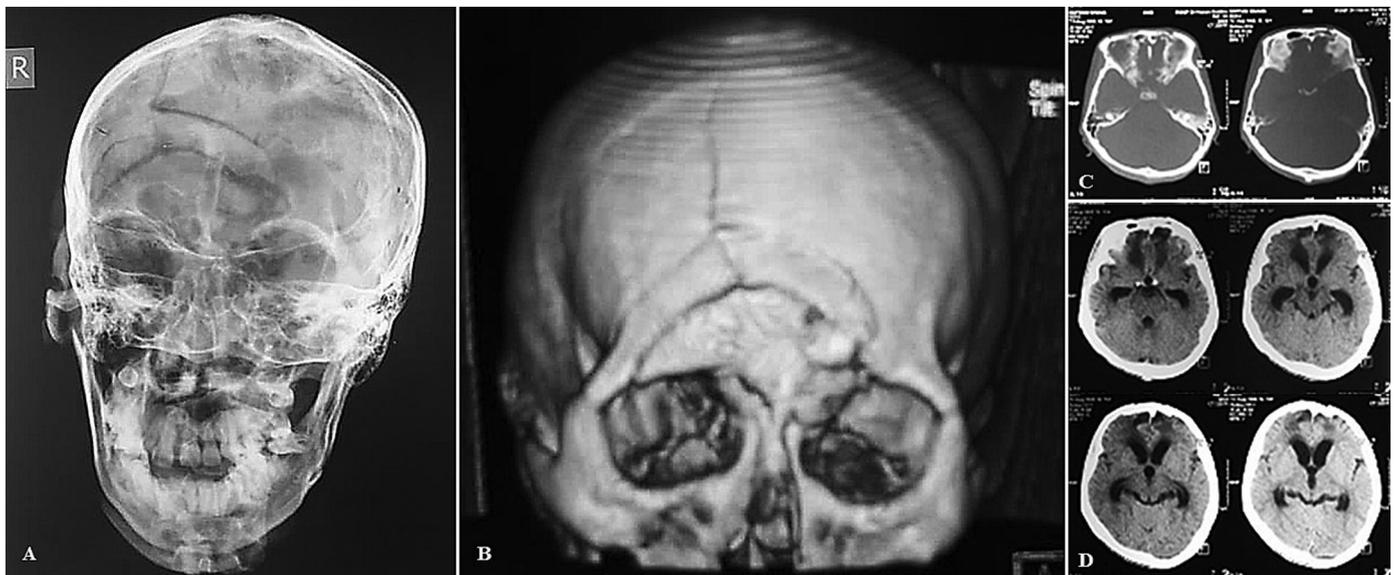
Skull X-ray performed immediately after the accident shows multiple fracture lines at a mid-frontobasal area with double contour, suggesting depressed skull fractures (A). CT bone window and 3D reconstruction showed depressed fractures at a mid-frontobasal area greater than the thickness of the skull (B), occupying frontal sinus with multiple fracture lines and bone fragmentation (C). CT scan images taken 3 weeks after the accident, showed enlargement of all ventricles with periventricular hypodensity.
